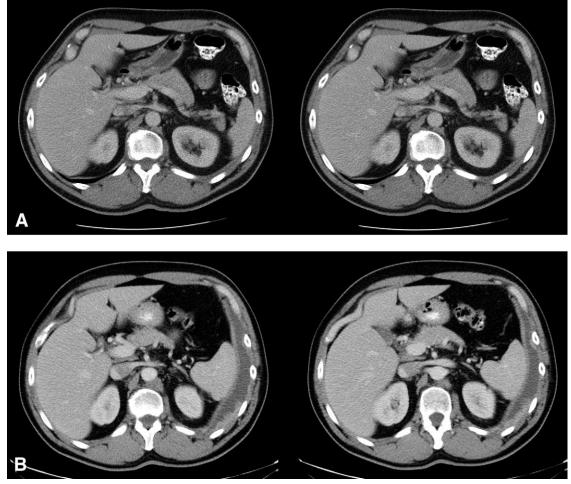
Axial CT scan of the abdomen without saline flush (A). The same patient then received a subsequent axial CT of the abdomen with the same amount of contrast media but with use of a saline flush (B). Increased enhancement of the abdominal aorta as well as visceral organs are demonstrated.
